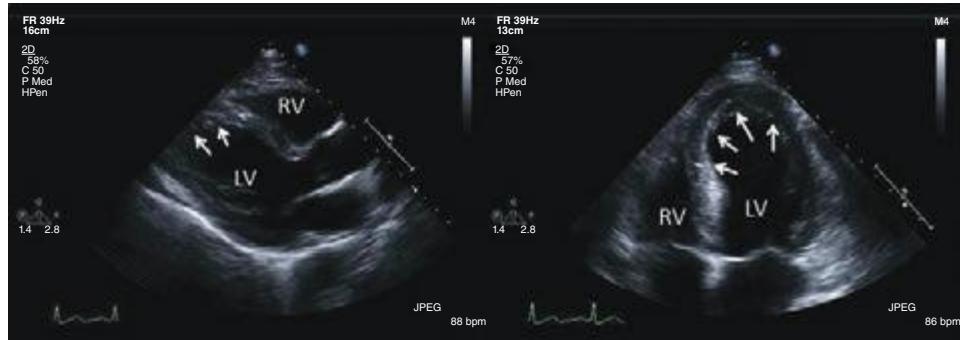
1 A 48-year-old man with new-onset substernal chest pain. Echocardiography shows evidence of acute anterior myocardial infarction involving the interventricular septum and apex secondary to an occlusion of the left anterior descending coronary artery seen from the parasternal long axis view (left) and the apical four-chamber view (right). LV, left ventricle; RV, right ventricle. ([See Videos 271e-1 and 271e-2.](#))
